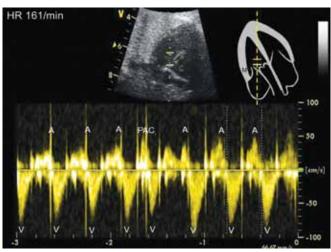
Premature atrial contraction, which gets conducted to the ventricles, is captured with simultaneous aortic and mitral Doppler
